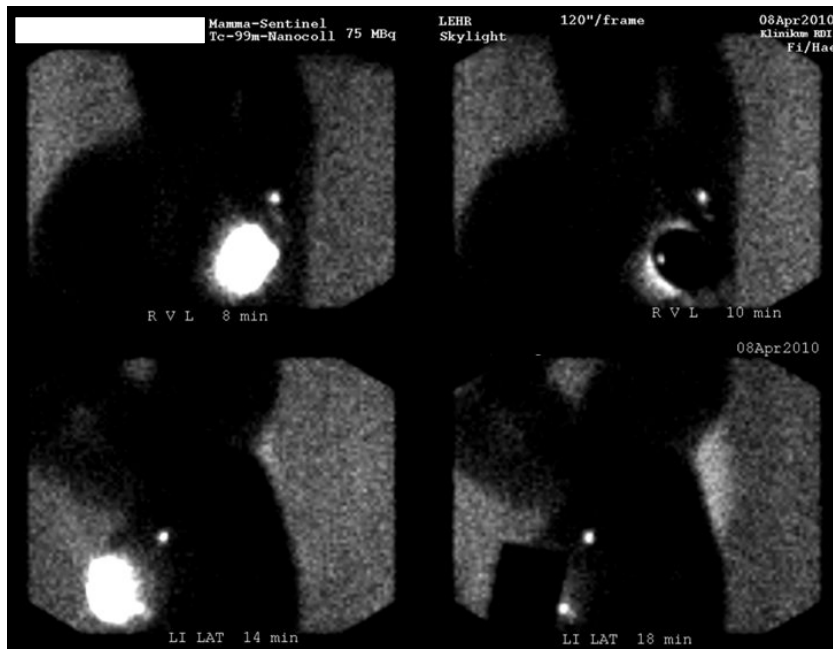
Exemplary summary scintigraphy image of a patient. The white rectangle on the top left is added to protect the name and birthdate of the patient which is initially included in the image similar to the other information on the top such as examination date or injected activity.
